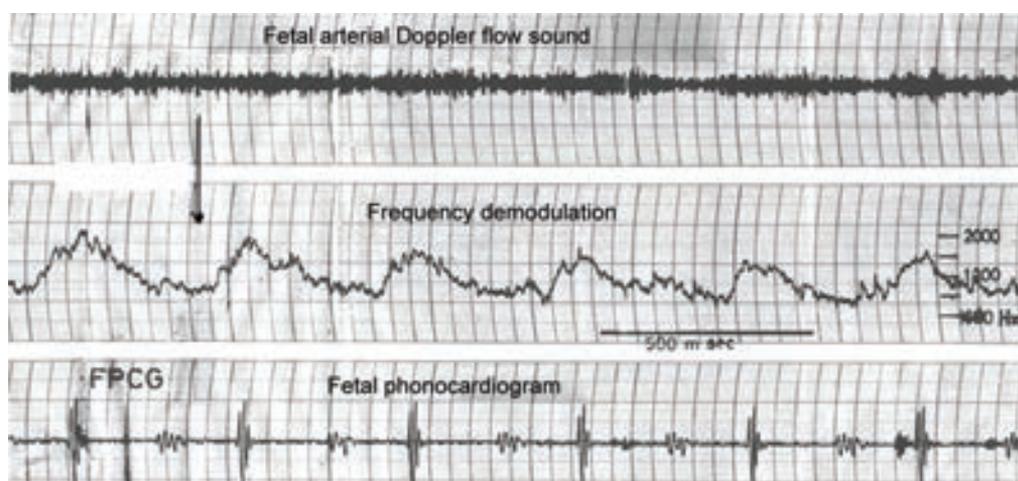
World first fetal arterial Doppler blood flow wave; 1st line: Doptone sound of fetal arterial blood flow; 2nd line: the CW Doppler fetal arterial blood flow wave, which was obtained by frequency demodulation of the first line signal; 3rd line was I and II fetal heart tones
